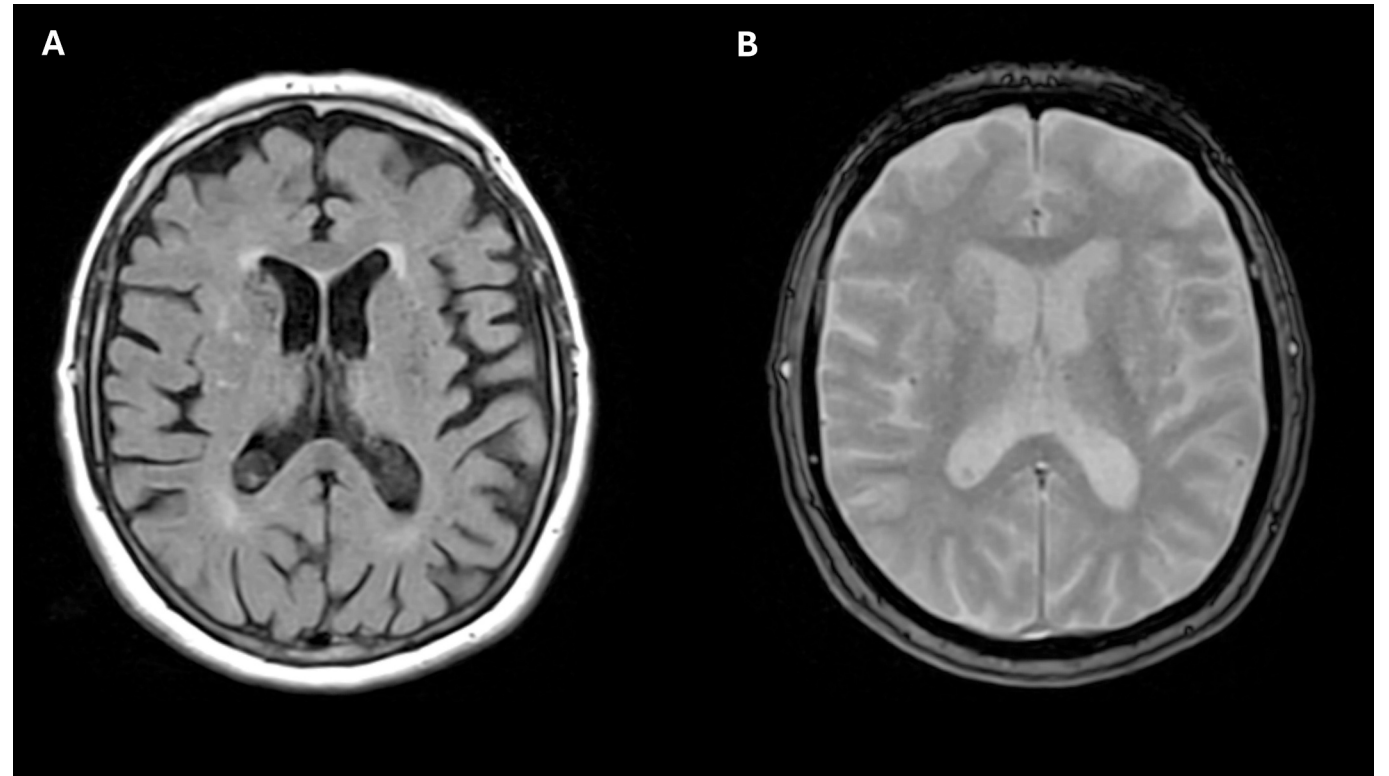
Brain MRI data A: Axial fluid-attenuated inversion recovery (FLAIR) sequence, revealing mild-to-moderate chronic small-vessel ischemic leukoencephalopathy without focal abnormalities. B: Gradient-echo (GE) sequence, showing no evidence of haemorrhagic lesions or other significant abnormalities.
